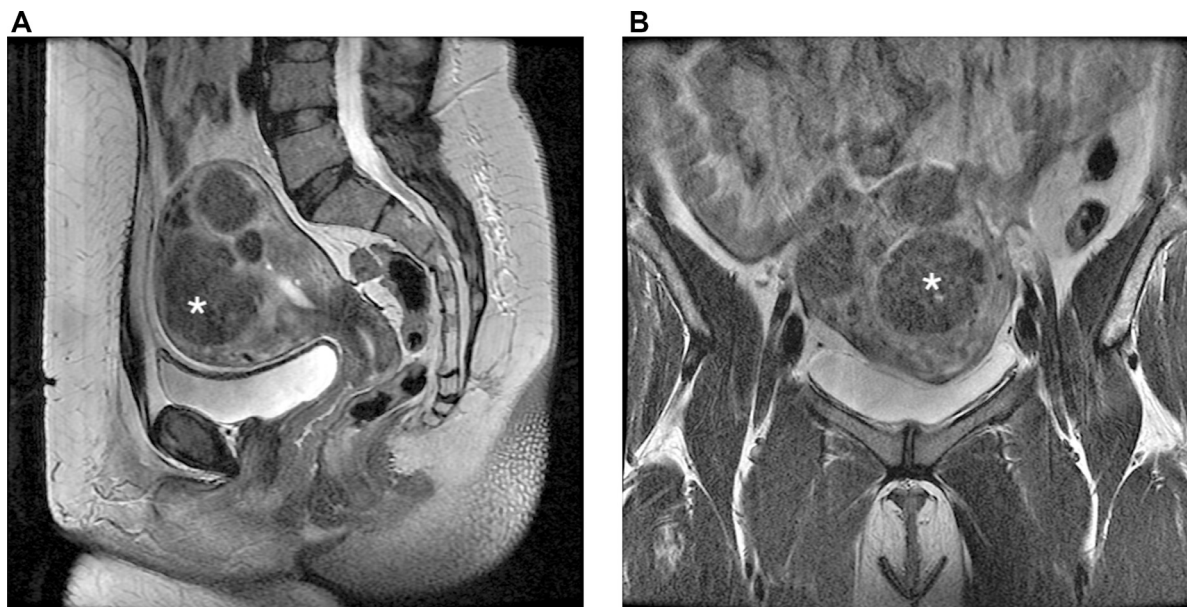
Sagittal (A) and coronal (B) T2-weighted MR images of a patient with pain due to multiple UFs. The biggest one is likely responsible for symptoms and thus is considered as the “dominant” fibroid (white star).
